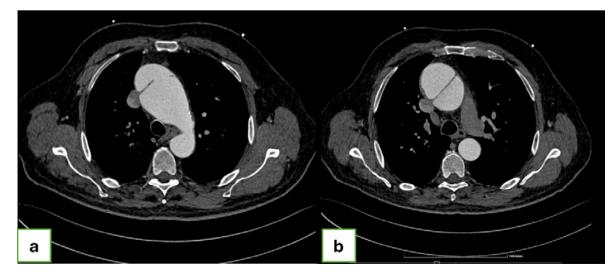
a) Pre - operative CT (Computed Tomography) scan showcasing the dissection of the ascending aorta extending to the origin of the brachiocephalic trunk. b) Preoperative CT (Computed Tomography) scan showcasing the dissection of the ascending aorta.
